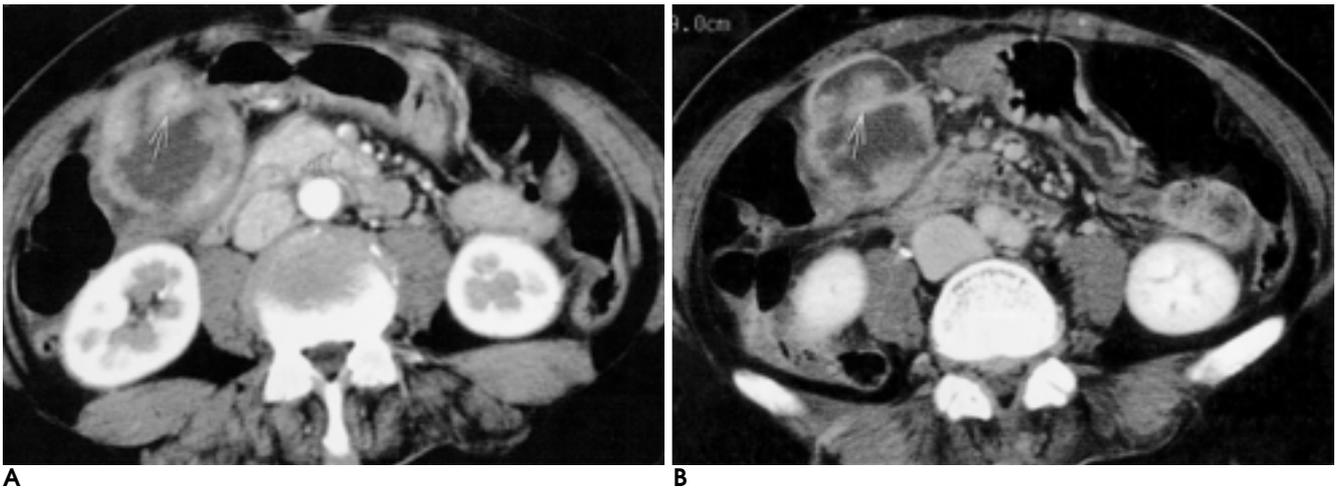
Gallbladder carcinoma. Two phase spiral CT scan shows thickened inner wall layer with high attenuation (arrow) on both the arterial (A) and venous phase (B) scans.
